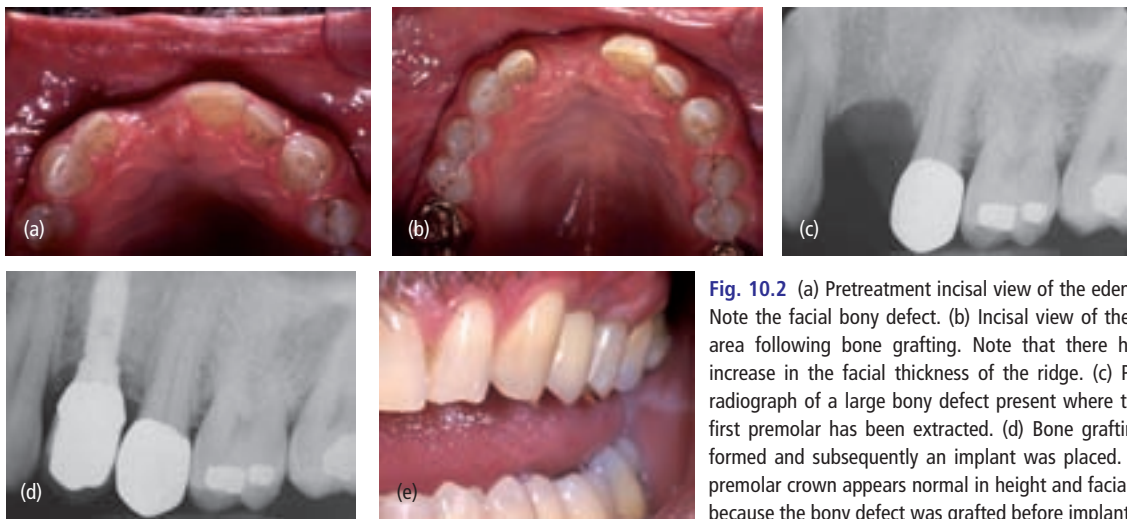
(a) Pretreatment incisal view of the edentulous area. Note the facial bony defect. (b) Incisal view of the edentulous area following bone grafting. Note that there has been an increase in the facial thickness of the ridge. (c) Pretreatment radiograph of a large bony defect present where the maxillary first premolar has been extracted. (d) Bone grafting was performed and subsequently an implant was placed. (e) The first premolar crown appears normal in height and facial positioning because the bony defect was grafted before implant placement.
